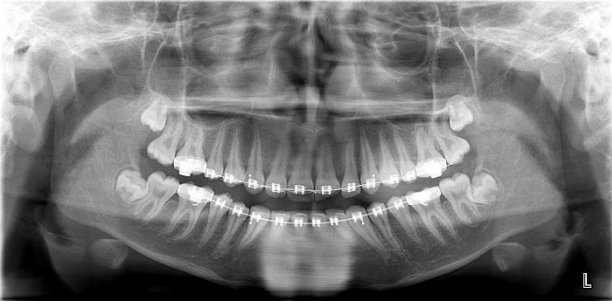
Pre-finishing orthopantomography.
